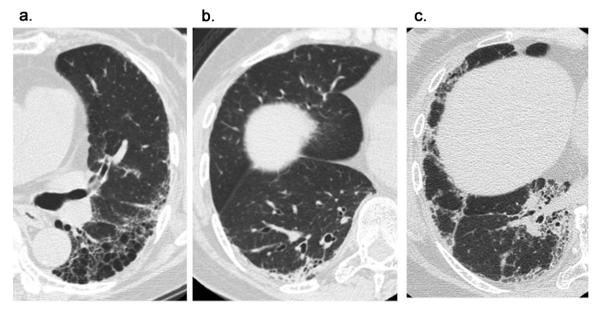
Reticular opacities. (a) Thin-section CT scan of the right lung in a 64-year-old woman with ARS-ILD (KS) shows reticular opacities in peripheral areas. (b) Thin-section CT scan of the right lung in a 59-year-old man with ARS-ILD (Jo-1) demonstrates reticular opacities in both peripheral and peribronchovascular regions. (c) Thin-section CT scan of the left lung in a 64-year-old woman with ARS-ILD (E) presents reticular opacities in both peripheral and peribronchovascular areas.
